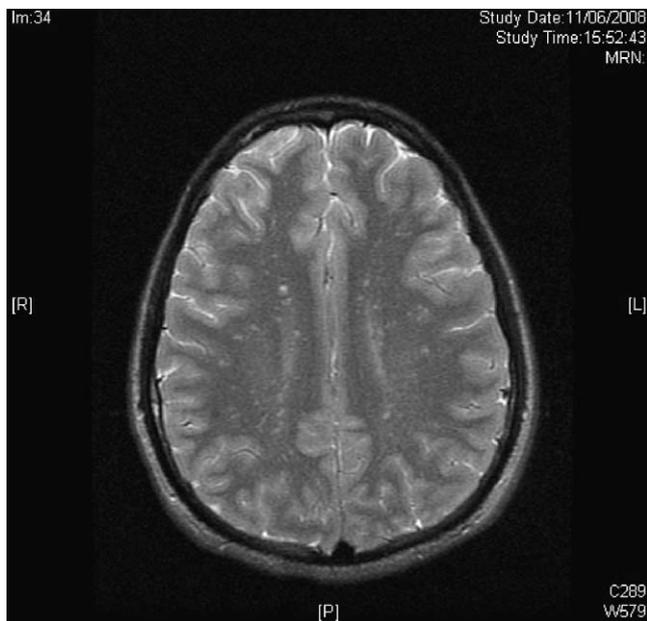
An MRI of the patient, showing high intensity signal abnormalities in the deep white matter.
